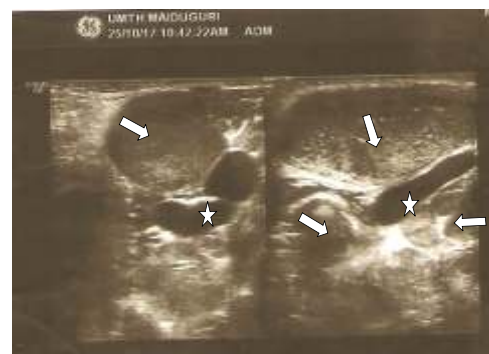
Abdominal ultrasonography (transverse and longitudinal views) showing multiple para-aortic lymph nodes (white arrows). Aorta was depicted by the white star.
